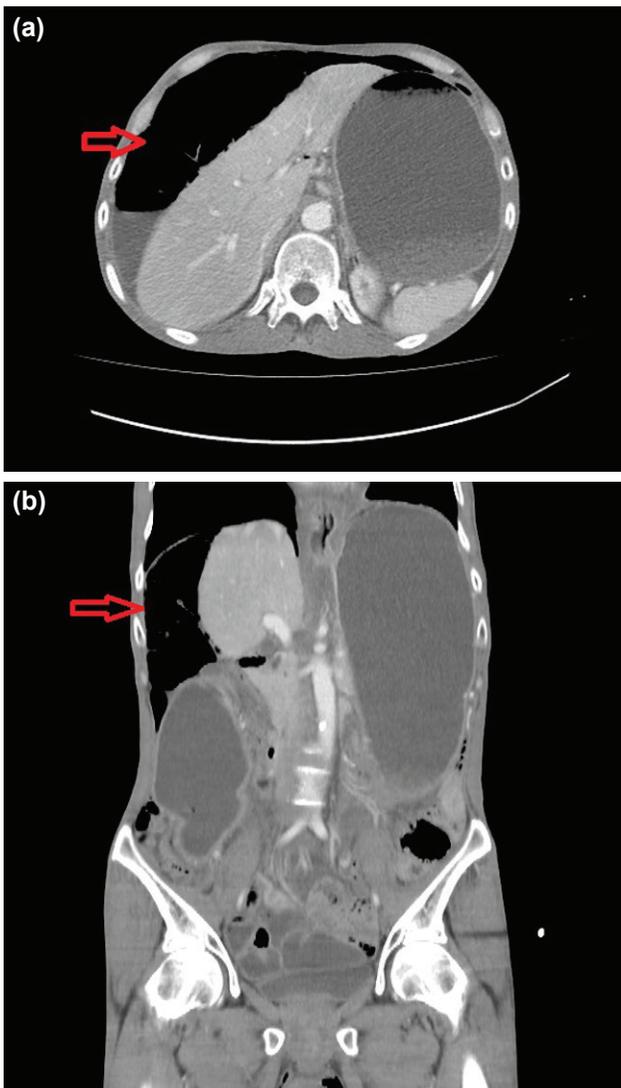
(a) Axial CT / (b) Coronal CT: Intestinal loop transposed between the diaphragm and liver (indicated by the arrow).
